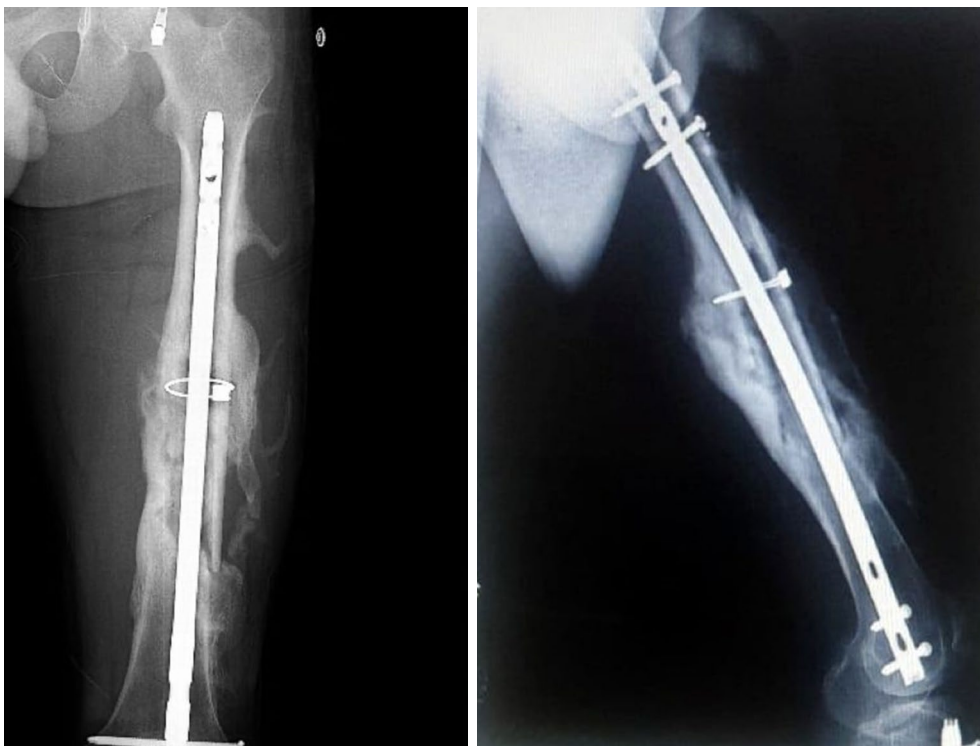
Anteroposterior and lateral radiographs of the femur fracture showing union.
